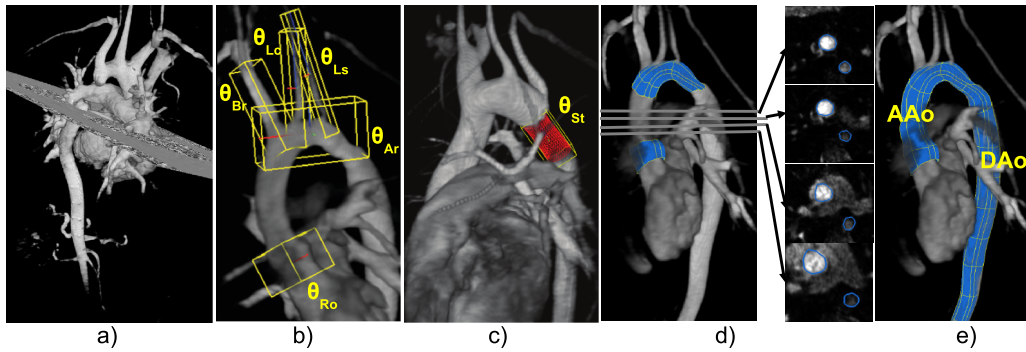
(a) Standard CoA MR exam with pair of images: 3D MRA and 2D + *t* PC-MRI. Note the MR signal drop-out at the stented isthmus. (b)  $\theta_o$  similarity transforms of model parts  $o \in \{Ro, Ar, Br, Lc, Ls\}$ . (c) Similarity transform and surface of stent model. (d) Shape models initialized at  $\theta_{Ro}$  and  $\theta_{Ar}$ , and circle tracking in axial slices to (e) initialize ascending- and descending aortic walls.
